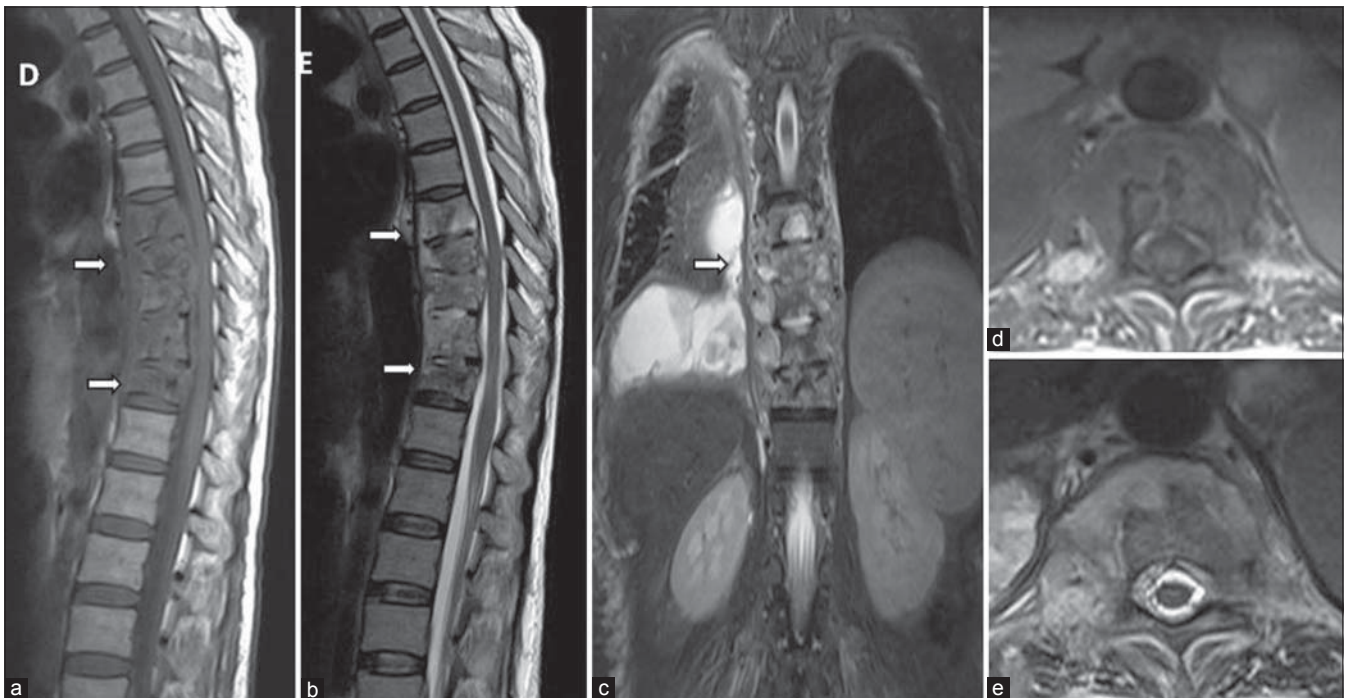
Magnetic resonance imaging dorsal spine sagittal T1W (a), sagittal T2W (b), coronal short-tau inversion recovery (c), axial T1W (d), axial T2W (e) in a 48 year female presenting with back pain and fever, with weakness in both lower limbs. American Spinal Injury Association Class D. Multilevel tuberculous spondylitis of D7-D11 vertebral bodies and bilateral pedicles (a-c). Intervening intervertebral discs involved. Epidural collection extending from D8 to D10 level measuring 10 mm in maximum thickness (b and e) and causing cord compression. Pre and para vertebral collection extending from D7 to D11 level (c-e). Right loculated pleural collection noted (c)
